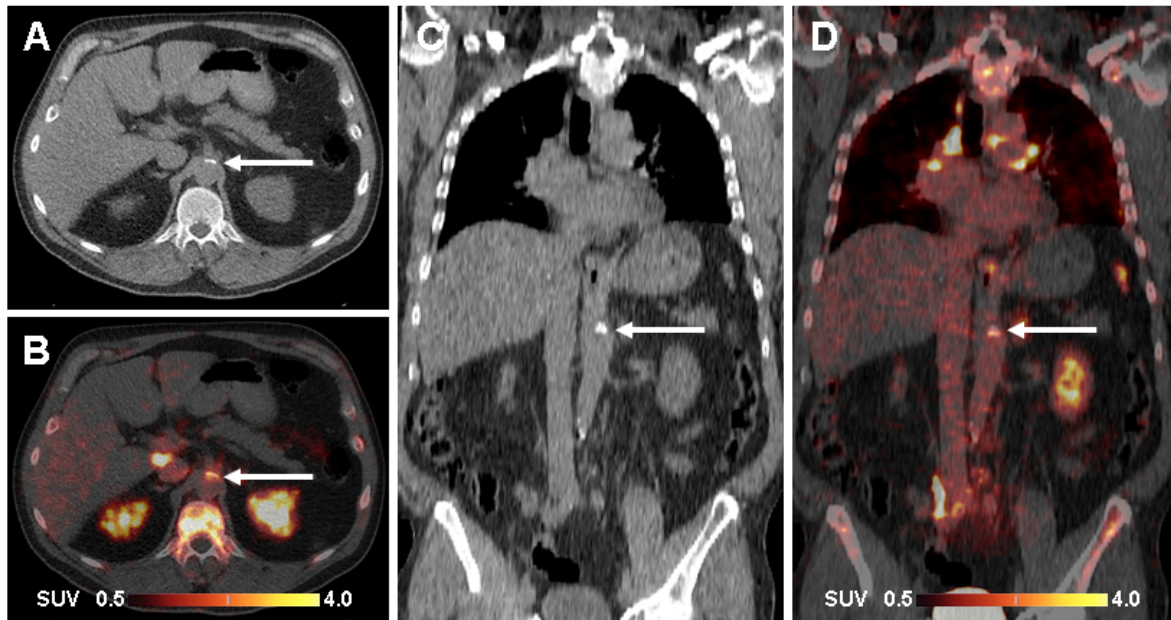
^{68}Ga -Pentixafor-PET/CT images of abdominal aorta in a 64-year-old woman. (A) Transaxial CT image and (B) fused PET/CT image showing ^{68}Ga -Pentixafor uptake in a partly calcified atherosclerotic lesion (arrow) in the wall of an atherosclerotic ectatic aorta. Sagittal CT image (C) and fused PET/CT image (D) showing additional foci of ^{68}Ga -Pentixafor uptake in non-calcified plaque (non-continuous arrow).
